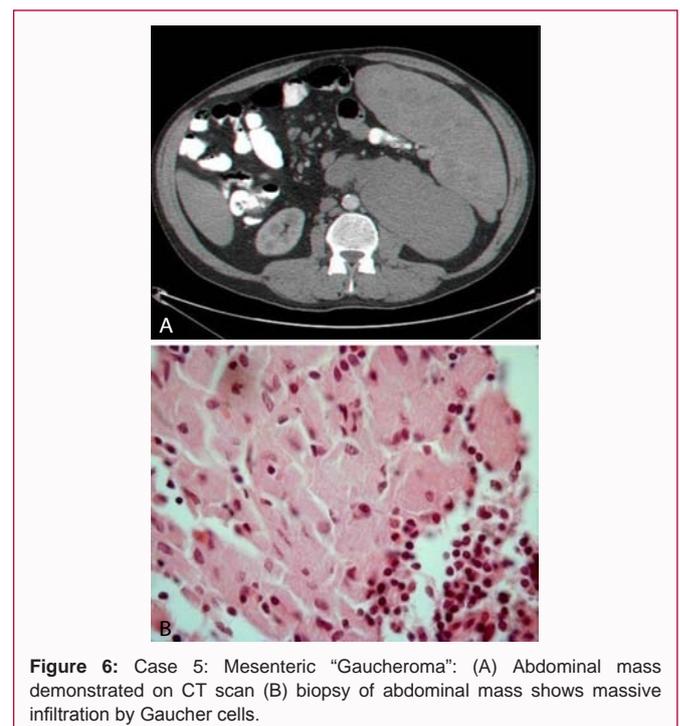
Case 5: Mesenteric "Gaucheroma": (A) Abdominal mass demonstrated on CT scan (B) biopsy of abdominal mass shows massive infiltration by Gaucher cells.
